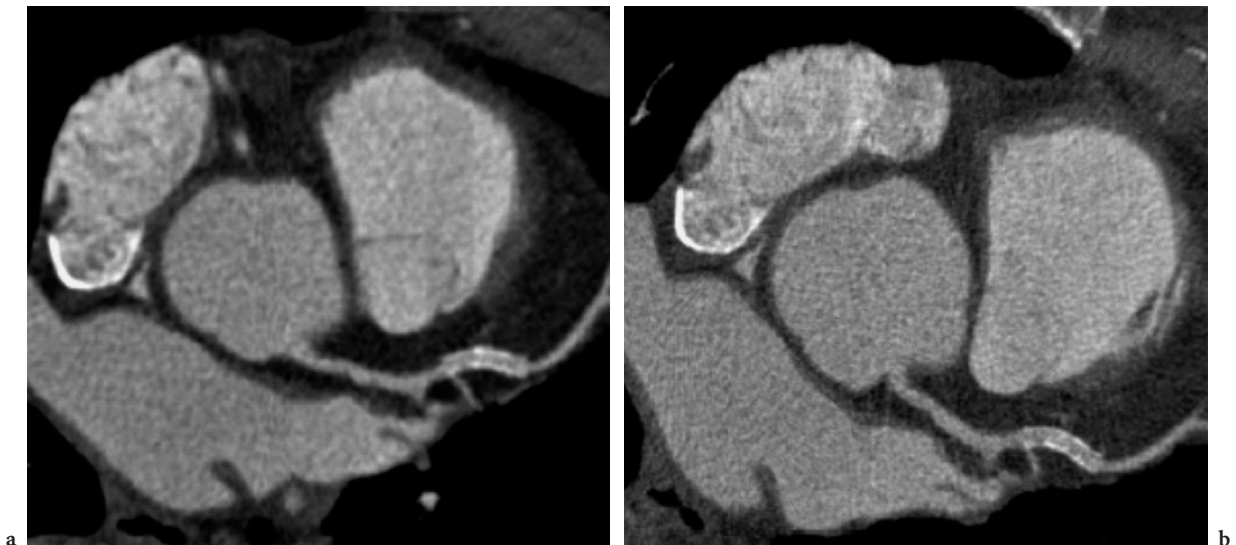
Coronary CT angiography examination of a patient with a stent (3-mm diameter) in the left anterior descending coronary artery. The examination was carried out using a 64-slice CT scanner with 0.6-mm collimation and 0.33-s rotation time. a Visualization of the in-stent lumen is compromised with 0.75-mm slice width and a medium-smooth reconstruction filter kernel. b Patency of the 3-mm stent can only be demonstrated using a special reconstruction technique consisting of a slice width of 0.6-mm and a special sharp reconstruction filter kernel. The in-stent lumen of stents with diameter < 3 mm often cannot be evaluated with currently available 64-slice CT scanners. (Case courtesy of Erlangen University, Germany)
